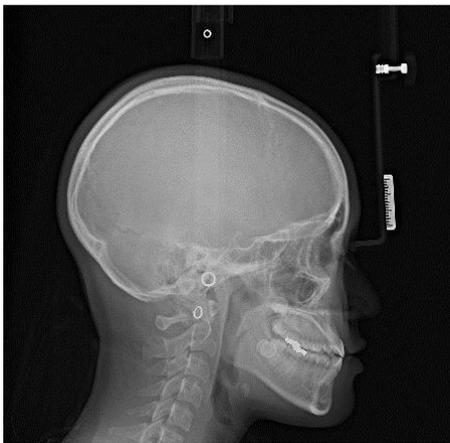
Lateral Cephalometric radiographic image showed a radiolucent lesion in the anterior mandible.
